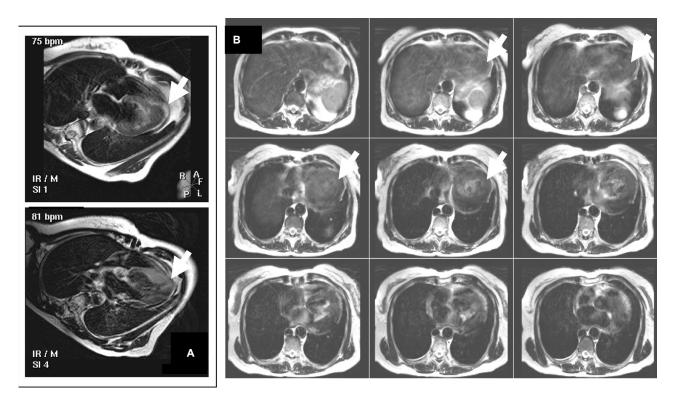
(A) Dual inversion spin-echo images (TI: 330 msec, TE: 100 msec, TR: 1500 msec, turbo factor: 31) of the left ventricle in the 4-chamber orientation. (B) Contiguous transverse T2-weighted fast spin echo images (TE: 120 msec, TR: 2250 msec, turbo factor: 18), covering the entire heart. With both imaging approaches, focal apical hypertrophy (arrows) can be readily identified.
